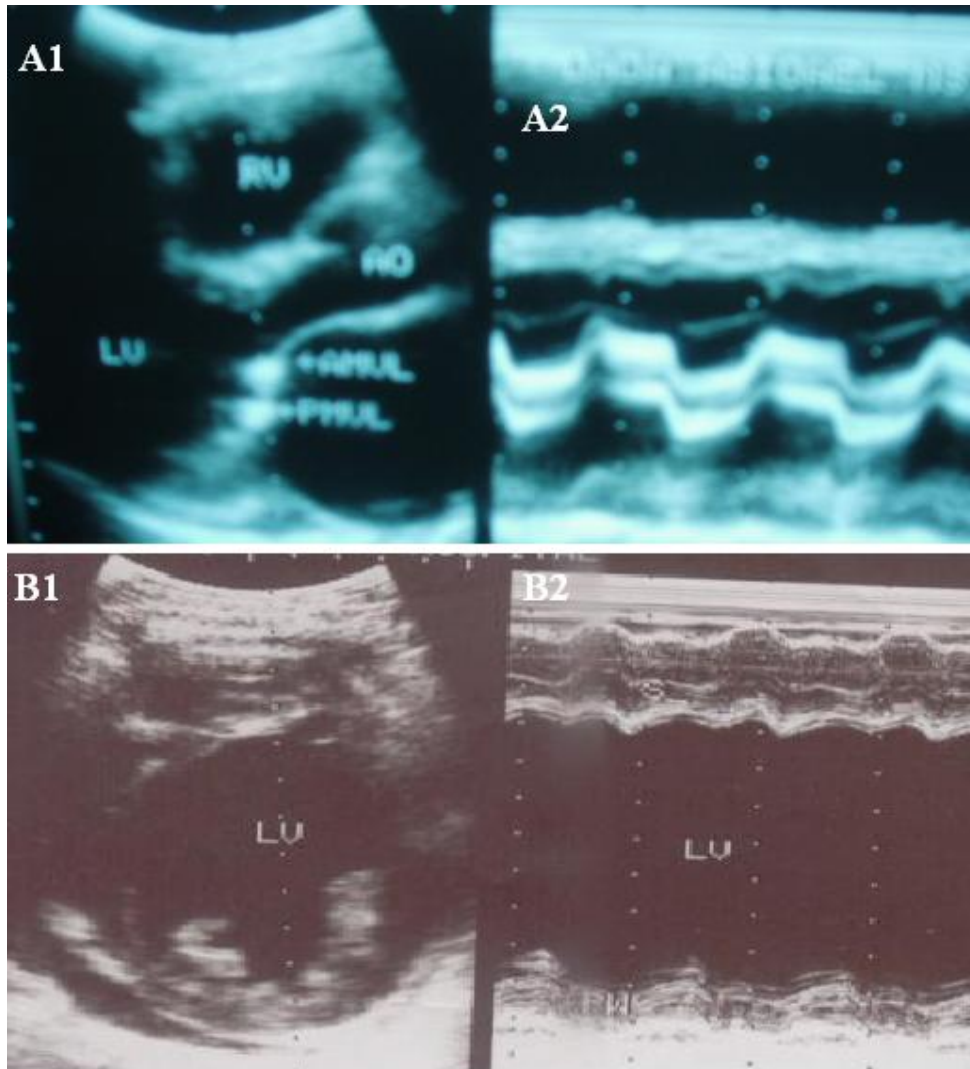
A(1&2). 2D and M-mode echocardiogram of a subject with mitral stenosis; B(1&2). 2D and M-mode echocardiogram of a subject with idiopathic dilated cardiomyopathy
